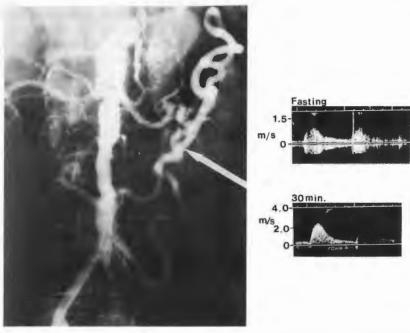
The angiogram demonstrates a large splanchnic artery collateral vessel in a patient with ostial occlusions of both the SMA and the CA. Thirty minutes after a 350-calorie, mixed-nutrient meal, PSV in the collateral vessel increased from 108 to 260 cm/sec (141%). End-diastolic velocity increased from 22 cm/sec to 49 cm/sec (123%). (*From* Moneta GL, Cummins C, Castor J, et al: Duplex ultrasound demonstration of postprandial mesenteric hyperemia in splanchnic circulation collateral vessels. J Vasc Tech 15:37–39, 1991; with permission.)
